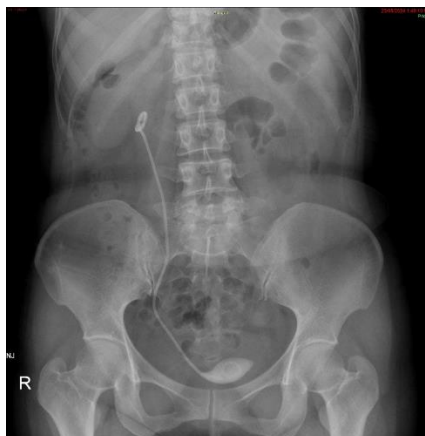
X-Ray of Kidney Ureter Bladder showing large Bladder stone with encrusted Double J stent
